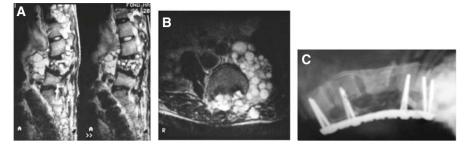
A, B T2-weighted sagittal and axial MRI. Lumbosacral spine hydatid disease. C Postoperative X-ray one year after surgery (L3 laminectomy with posterior osteosynthesis); albendazole therapy
